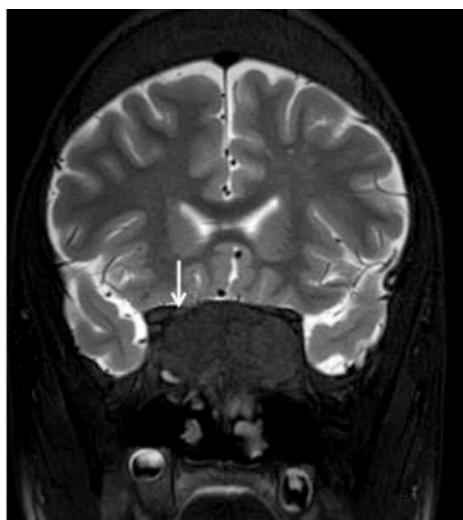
MRI of the orbit and brain. (A) Coronal T2-weighted showing compression and stretching of bilateral prechiasmatic optic nerves (arrows). (B) Coronal T2-weighted showing reduction in the size of the tumor-like expansion along with improvement of compression and stretching of bilateral prechiasmatic optic nerves (arrows).
